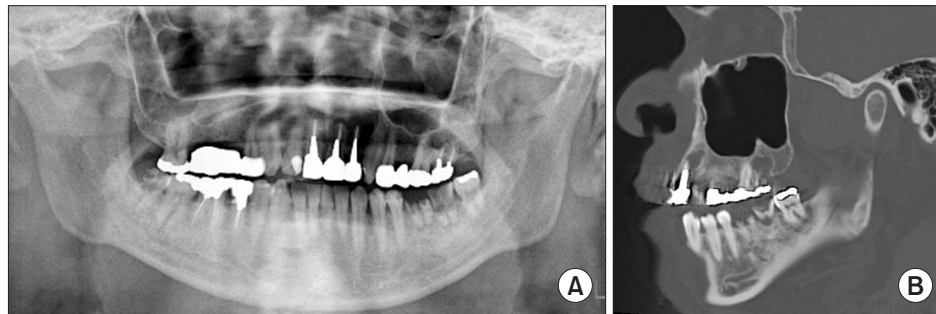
Imaging findings. A. Original panoramic X-ray findings. Periapical lesions are observed in the apical area of the right mandibular third molar, left mandibular first and second molars, and left maxillary central incisor. B. Computed tomography findings (sagittal section image). Cyst-like images are observed in the apical area of the left maxillary lateral incisor and second molar.
